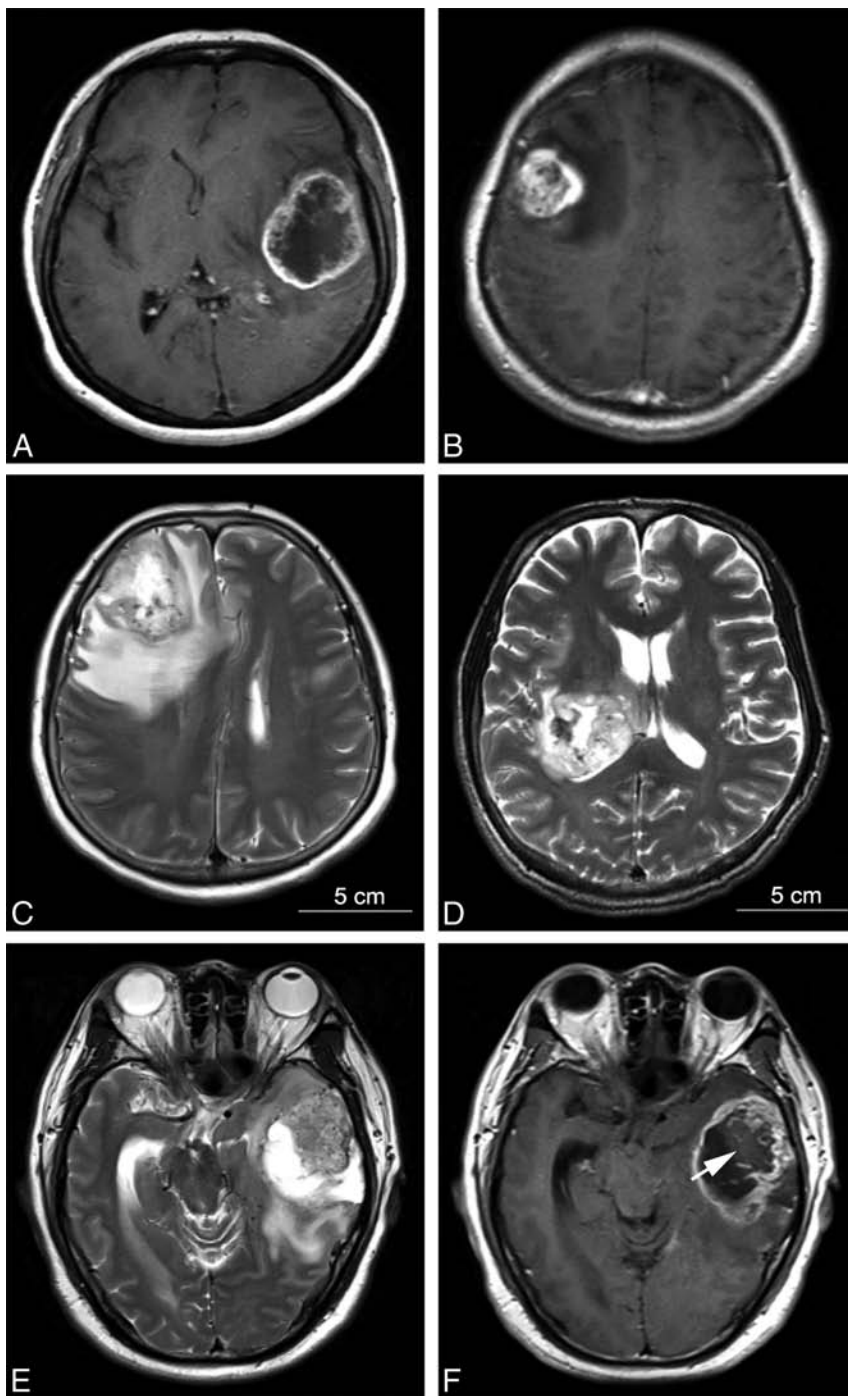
MR imaging features of patients with glioblastoma. The contrast-enhanced T1-weighted images showed ringlike contrast enhancement (A) and non-ringlike contrast enhancement (B). T2-weighted images show obvious peritumoral edema (+) (C) and little (or absent) peritumoral edema (–) (D). The non-contrast-enhancing tumor component refers to the tumor region of T2 hyperintensity (less than the intensity of CSF) (E) that was not enhanced on the contrast-enhanced T1-weighted image (white arrow) (F).
